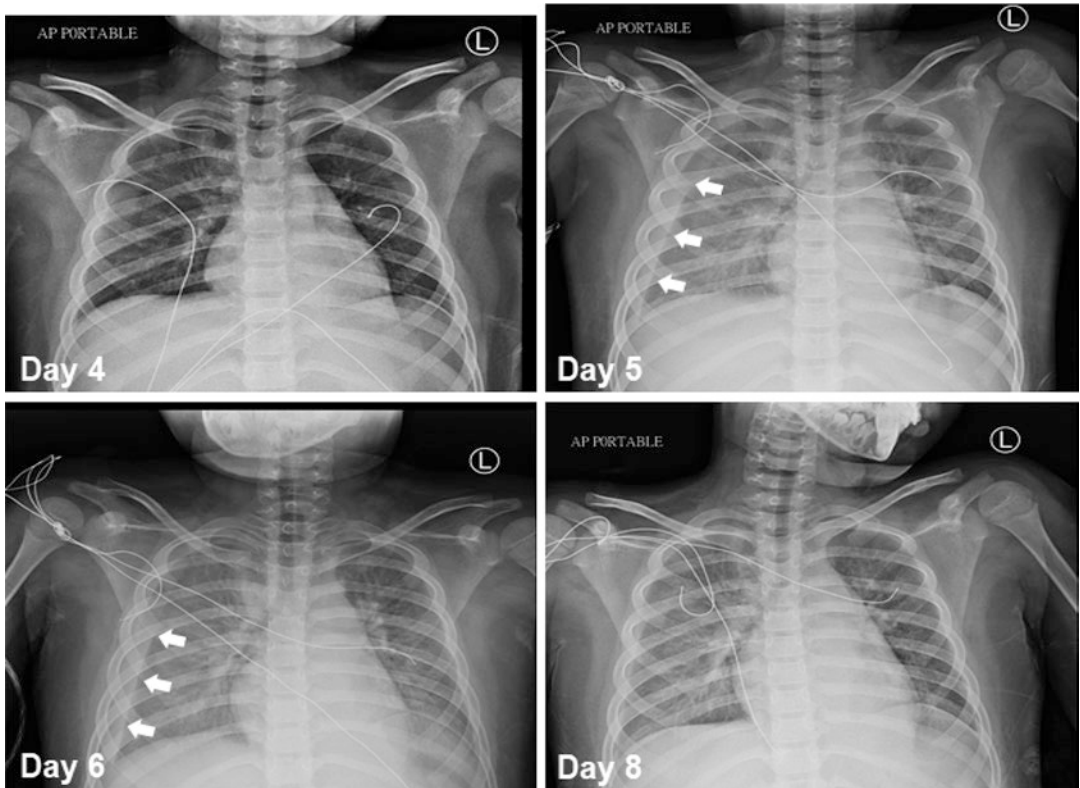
CXR series in an 8-year-old boy with dengue shock syndrome. Day 0: first day of fever, CXR: Chest X-ray, arrows: pleural lines
